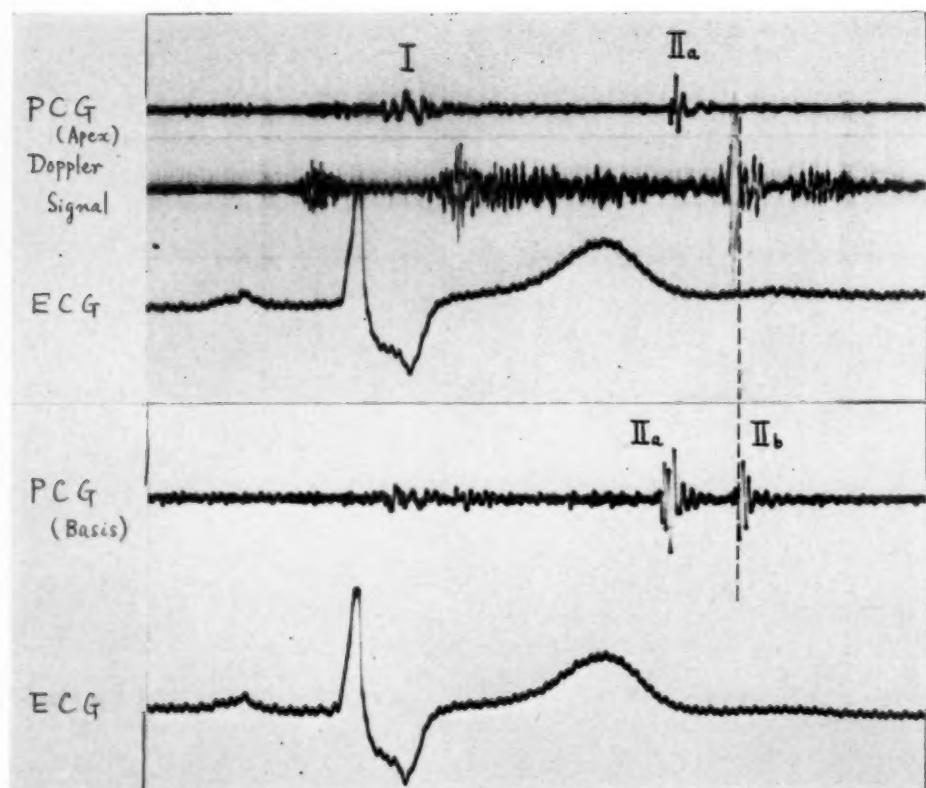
Delayed closing of the pulmonic valve in RBBB. Second basal sound is reduplicated. Its earlier component IIa is interpreted as being due to the aortic valve; its later component IIb is due to the pulmonic valve. The latter does not appear in the apical region. Doppler signal Pc has been obtained in the second intercostal space at the left sternal edge. Its end coincides, as expected, with the beginning of IIb . (H. A., a 30-year-old man.)
